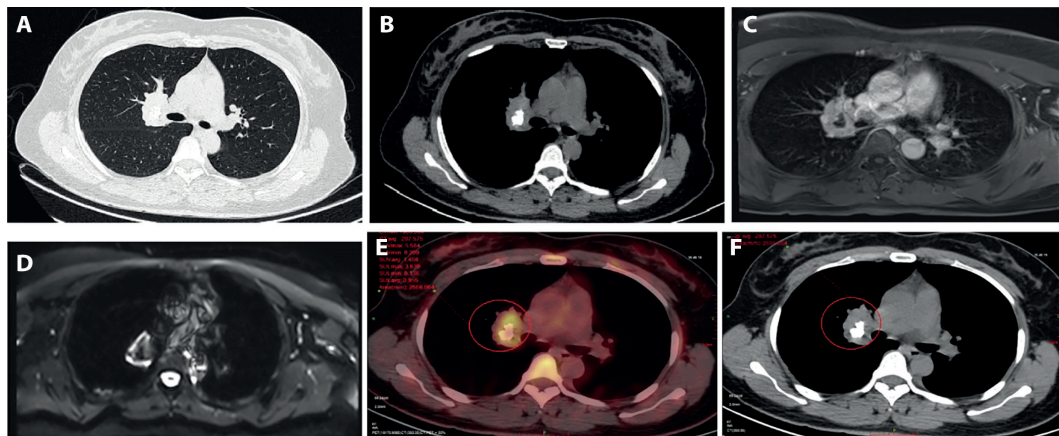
Imaging characteristics of intrapulmonary unicentric Castleman's disease. (a-b) Chest CT revealed a mass with soft tissue density and calcification in the right pulmonary hilum. MRI revealed the presence of a circular high signal in the hilum of the right lung, which was observed on both T1-weighted (c) and diffusion-weighted (d) images. (e-f) PET/CT revealed an irregular mass with coarse calcification within the right upper pulmonary hilum, encompassing the pulmonary artery and bronchus in the right upper lobe of the lung.
